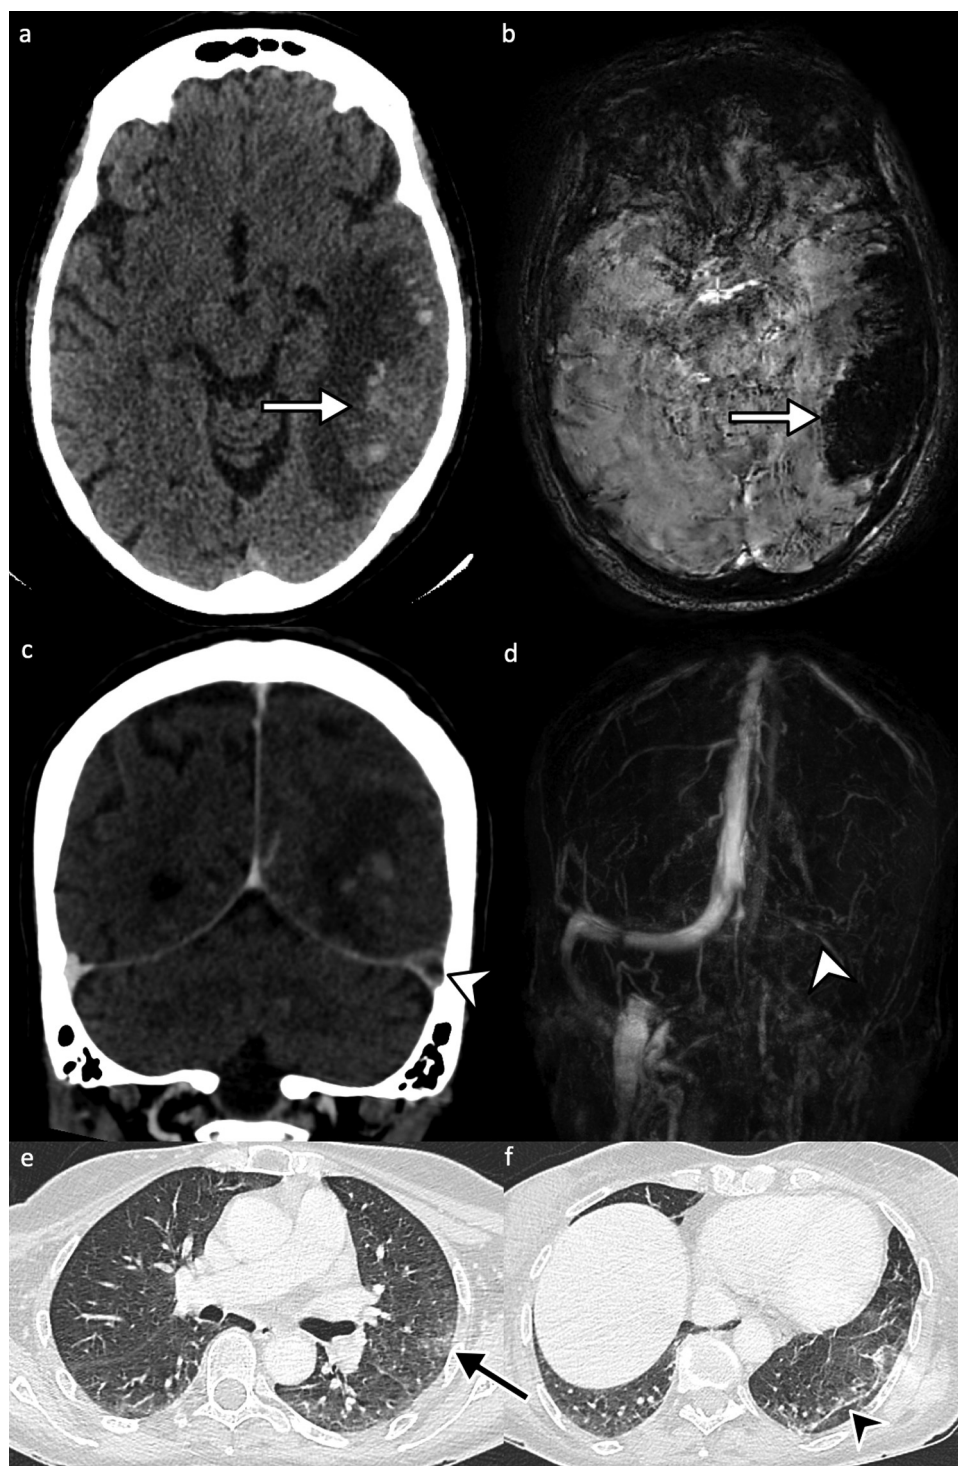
Patient 2. Non-contrast brain CT (a) and brain susceptibility-weighted MRI (b) revealed large hemorrhagic infarction of the left temporal lobe (white arrows). CT venogram (c) and MR venography (d) demonstrated filling defect in the left transverse sinus (white arrowheads) confirming CVT. CT-scan demonstrated subpleural ill-defined ground-glass (black arrow) and linear opacities (black arrowhead), highly suggestive of COVID-19.
